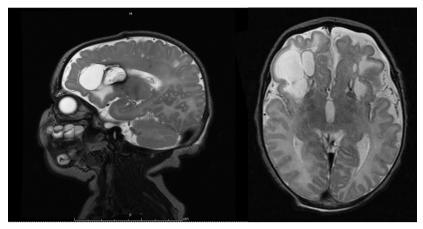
Sagittal (*left*) and axial (*right*) T2-weighted imaging showing multiple cystic changes in a 3-day-old girl with isolated sulfite oxidase deficiency.
